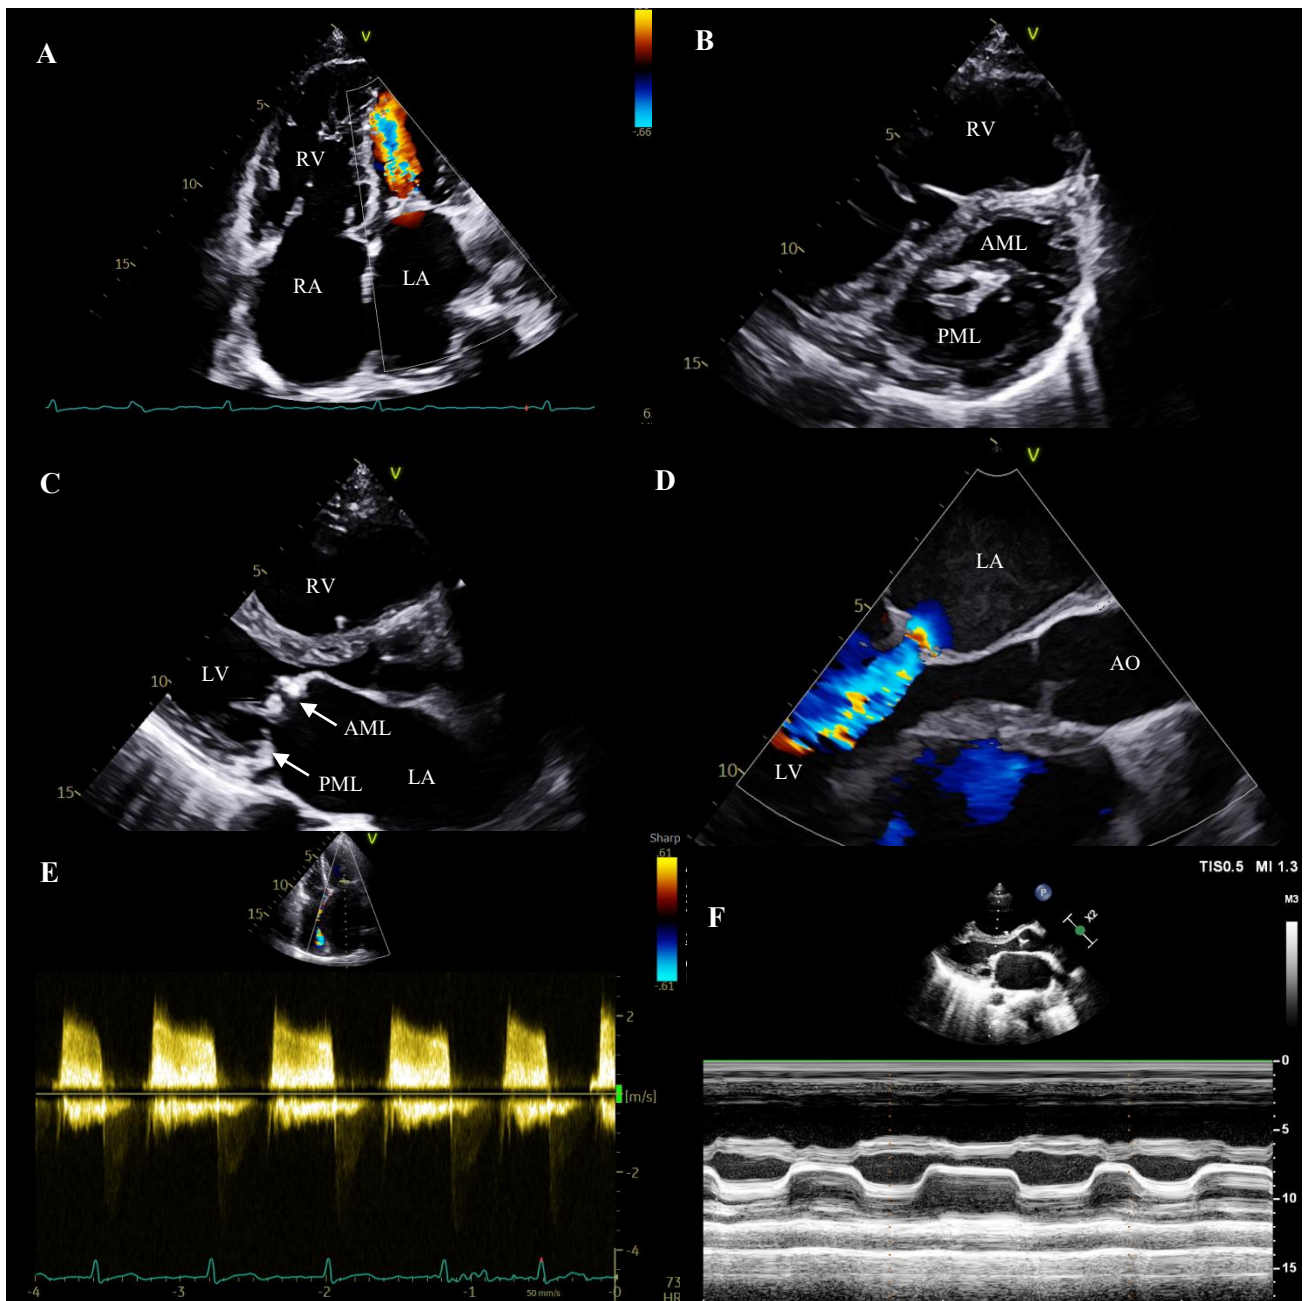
(A) TTE Apical-four-chamber view showing restricted leaflet motion during diastolic phase, (B) TTE Parasternal short-axis view showing commissural fusion with calcification, (C) TTE Parasternal long-axis view showing “hockey-stick or doming” appearance during diastolic phase and also thickening and shortening of chordae tendinae, (D) TEE parasternal long-axis view showing mitral stenosis, LA dilation, and spontaneous echo contrast (SEC) at the left atrial. (E) Continuous wave doppler in the severe MS, (F) M-mode showed thickened and calcified leaflet with decreased E-F slope. TTE = Transthoracic Echocardiography; TEE = Transesophageal Echocardiography; LA = Left Atrium; RA = Right Atrium; RV = Right Ventricle; AML = Anterior Mitral Leaflet; PML = Posterior Mitral Leaflet.
